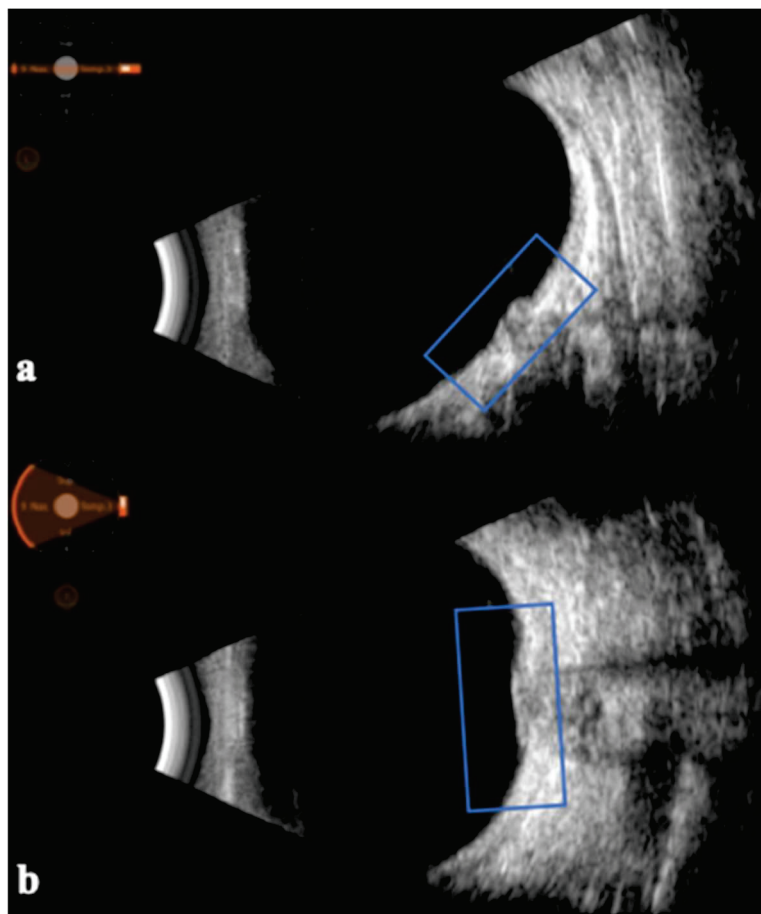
B-scan ultrasonography of the optic nerve insertion in the sagittal (a) and transversal (b) planes in a patient with papilledema. It is possible to observe the prominence of the optic disc (blue box).
